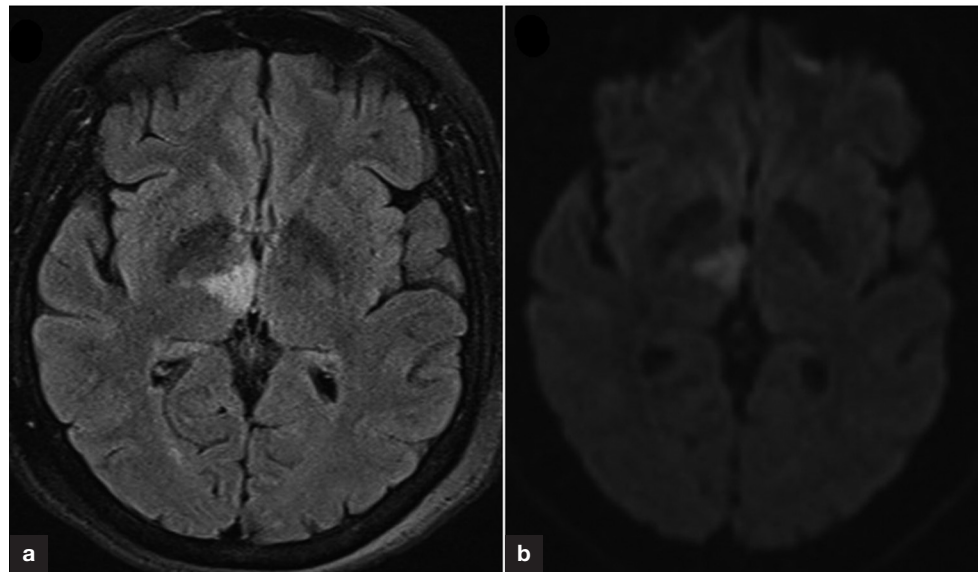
Magnetic resonance imaging of the brain. a. Fluid attenuation inversion recovery sequence shows a medial thalamic hyperintensity. b. Diffusion-weighted image shows a corresponding restricted diffusion consistent with an acute right median thalamic infarct.
